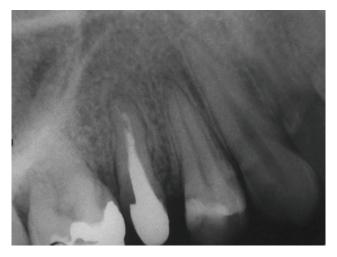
Radiograph confirms indication for tooth extraction
